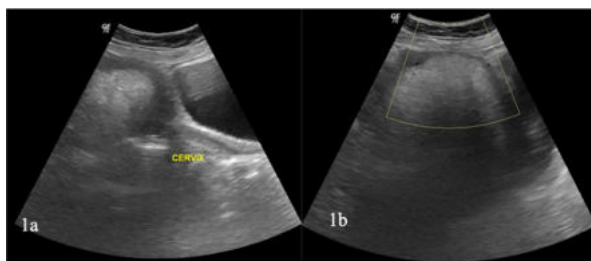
& 1b) : USG images showing echogenic lesion partially enclosed by hypoechoic rim representing myometrium. Mass was showing poor vascularity on colour doppler.
